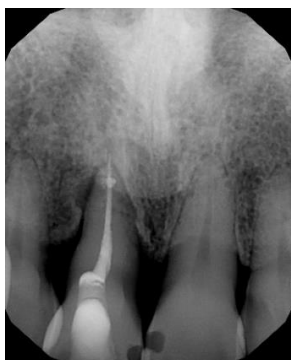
Periapical radiograph, 1 month postoperative.
